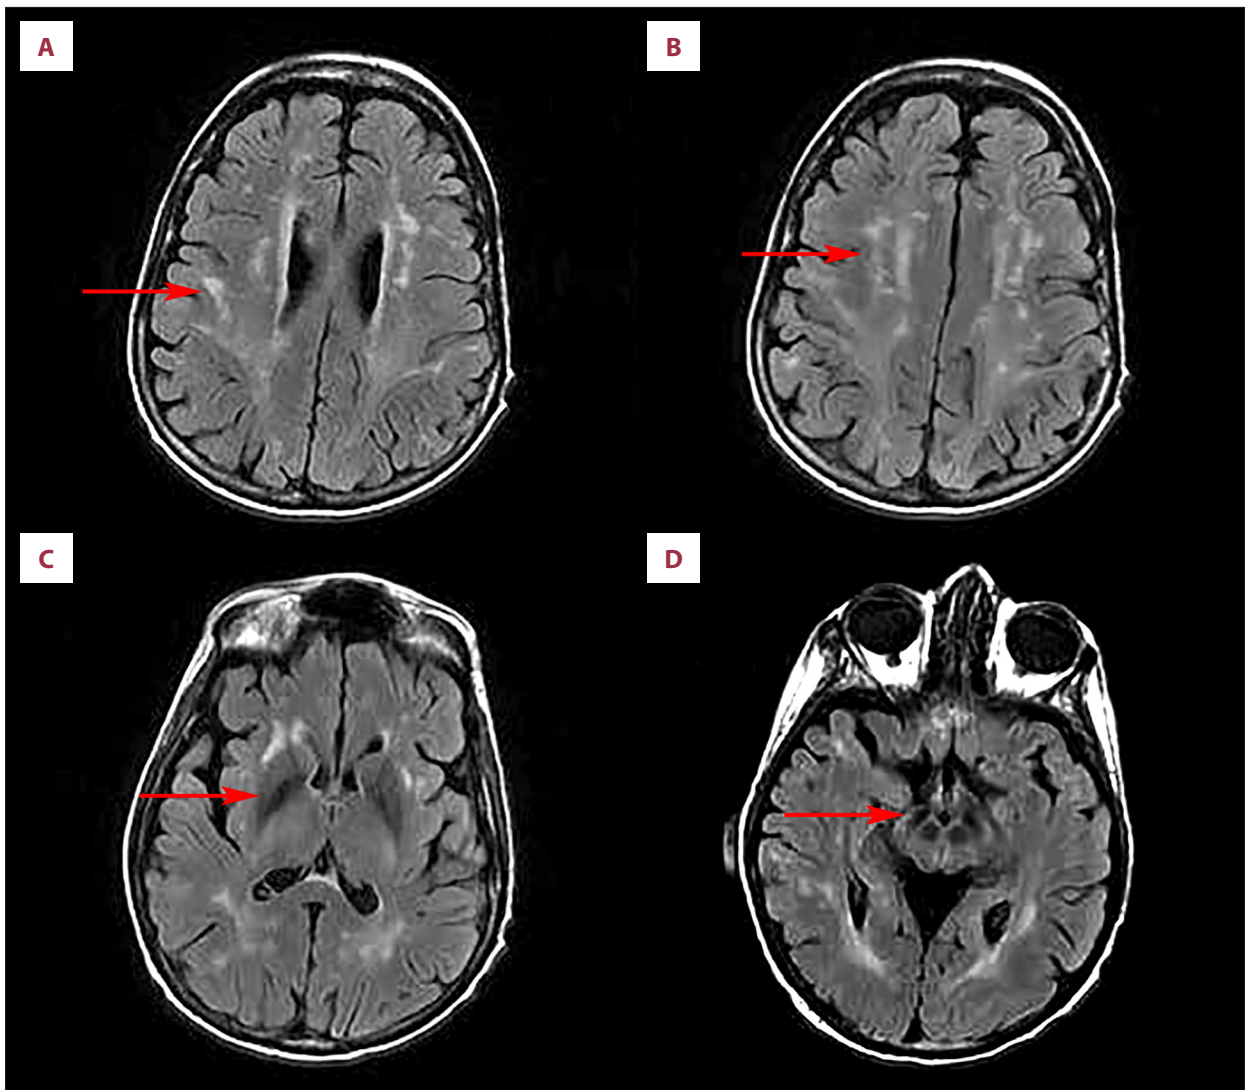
Magnetic resonance imaging axial T2 fluid attenuated inversion recovery. (A, B) Innumerable areas of T2 hyperintensity in the subcortical and deep white matter of both cerebral hemispheres. (C, D) Susceptibility signal in the bilateral globus pallidi and substantia nigra pars reticulata, suggestive of iron accumulation.
